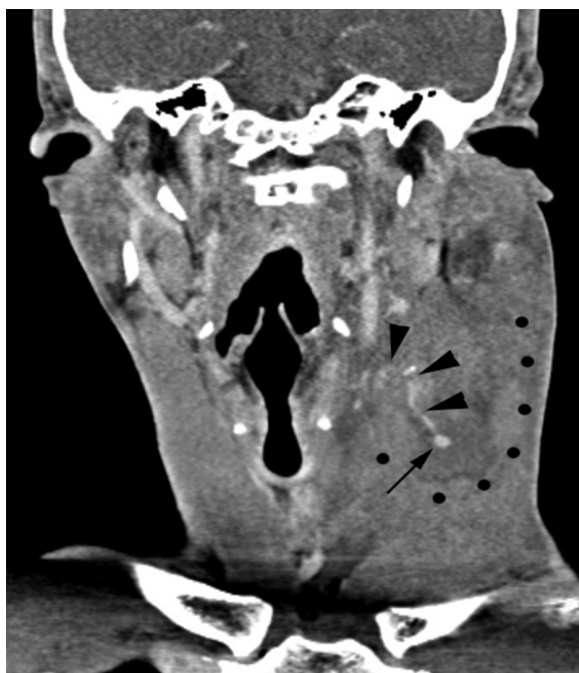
Coronal reformatted contrasted computed tomography of the neck showing an opacified artery (arrowheads) demonstrating a hairpin turn that leads to a focal ovoid region of active contrast extravasation (arrow) within the neck haematoma (its inferolateral margin is marked by dotted lines).
